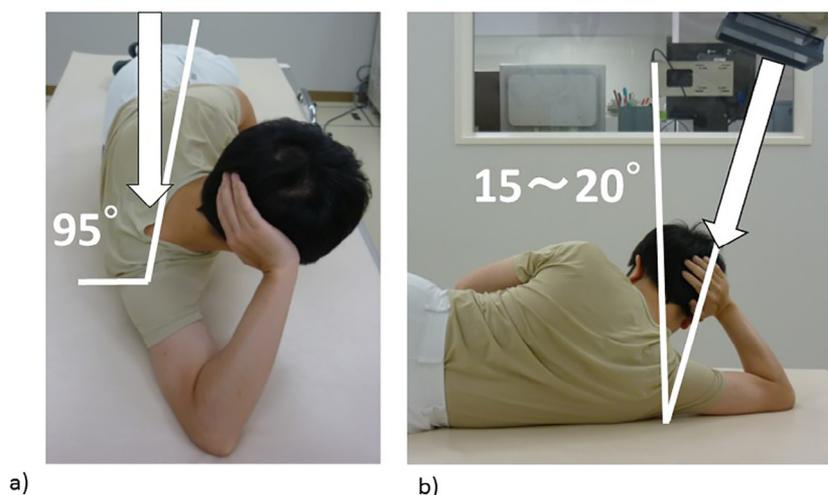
(a) The modified Bernageau imaging method is shown, with the patient placed in a side-lying position, with the affected shoulder in abduction and the palm of the hand placed behind the head, with the scapula oriented at 95° to the cassette. (b) The cassette is placed at a distance of 100 cm from the x-ray tube, with the tube placed at an angle of incidence of 15°-20° caudally. The arrow indicates the direction of the x-ray beam.
